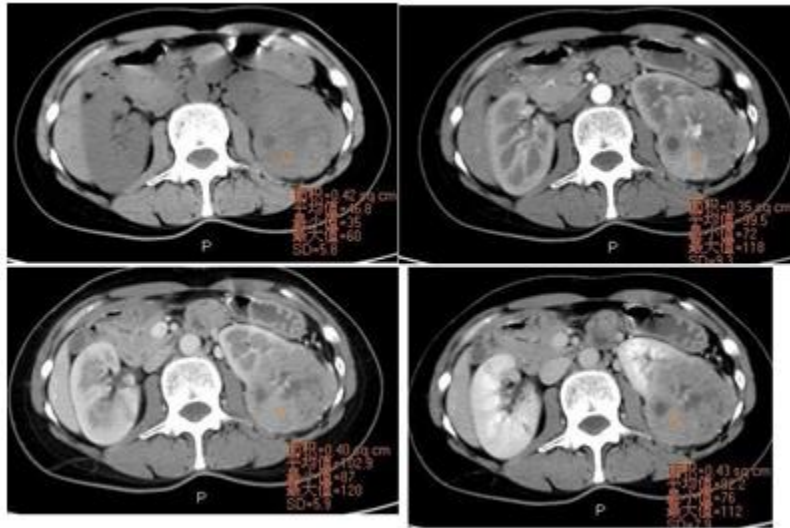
Female,45years, Left renal Unclassified RCC (sarcomatoid);(A). Heterogenous mass with irregular margin and necrosis seen in unenhanced phase with CT value of 46HU;(B). In corticomedullary phase the mass is heterogeneously enhanced with CT value of 99HU,tumor vessels seen;(C). The CTvalue of the same location is 102HU in parenchymal phase;(D). In excretory phase the CTvalue is 92HU.
